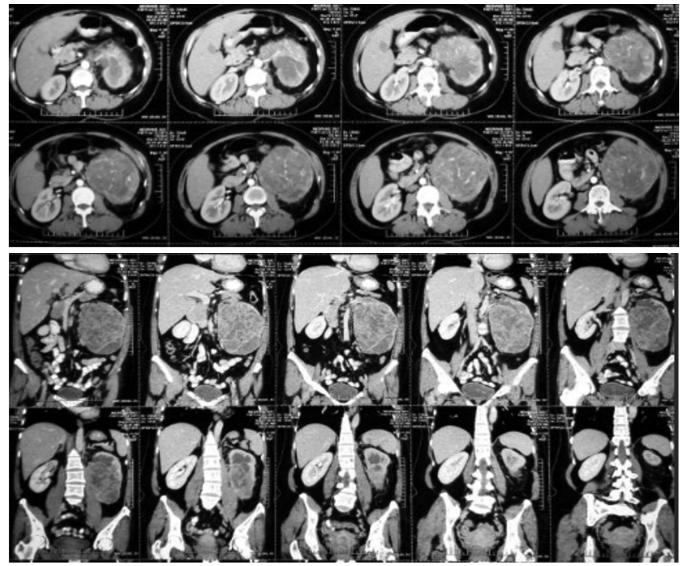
CT urogram showing a centrally located mass extending to the renal pelvis at the middle to lower aspect of the left kidney measuring 11.5cm x 9.5cm x 11.7cm.
